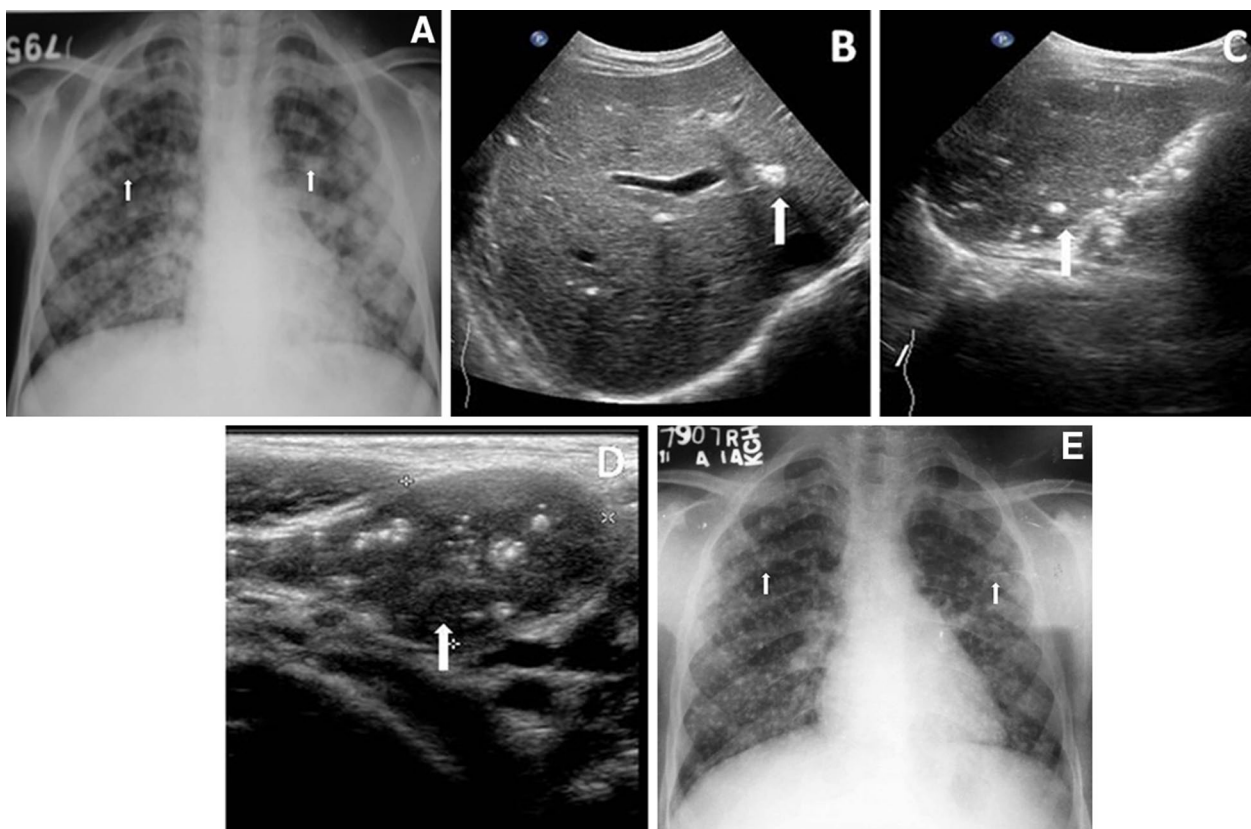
Tubercular Infection. Frontal chest radiograph in a 14-year-old male, a K/C/O HIV/AIDS, reveals diffuse ill-defined nodular air-space opacities throughout bilateral lung fields (arrows, A), few of them showing areas of confluence and calcification. Ultrasound abdomen in same patient shows calcified granulomas in liver (arrow, B), spleen (arrow, C) and conglomerated mesenteric lymph nodes with discrete calcifications (arrow, D). Patient's CD4 count was 655 cells/cu.mm. BAL isolated MDR-TB, Mantoux test was positive. Patient was put on ATT on the basis of these findings and showed significant clinical improvement. Follow-up (after 6 months) CXR shows resolution of nodular opacities and presence of multiple calcific lesions in bilateral lungs (arrows, E)
